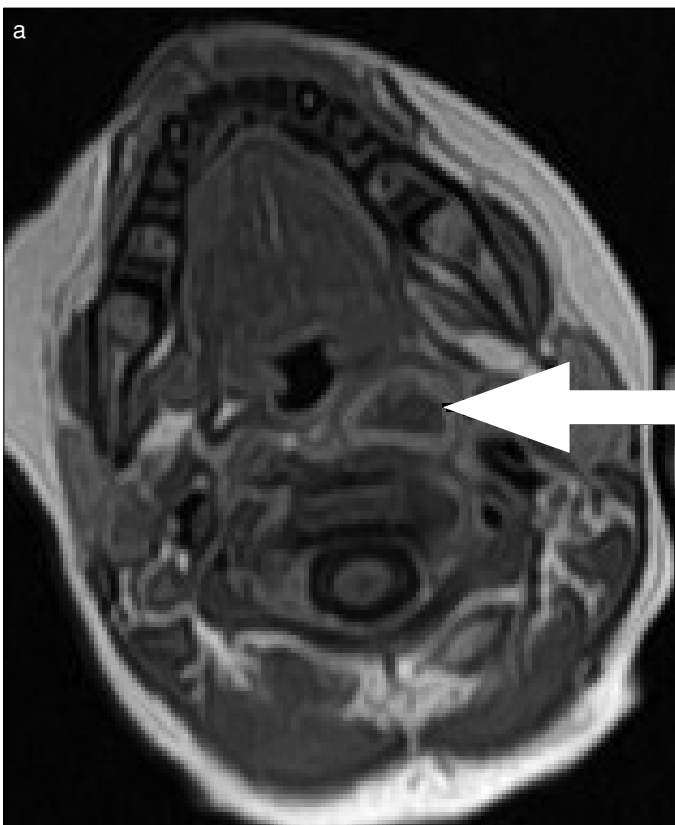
a, b. (a) In the contrast-enhanced computerized neck MRI examination, the image compatible with peripheral contrast involvement on the left retropharyngeal zone (Patient number 9) (b) In the contrast-enhanced computerized neck MRI examination, the image of sagittal incision, thickening in the soft tissue in the retropharyngeal zone and inflammation (Patient number 9)
